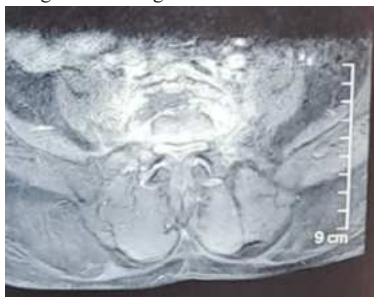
Contrast enhanced T2 axial MR image
